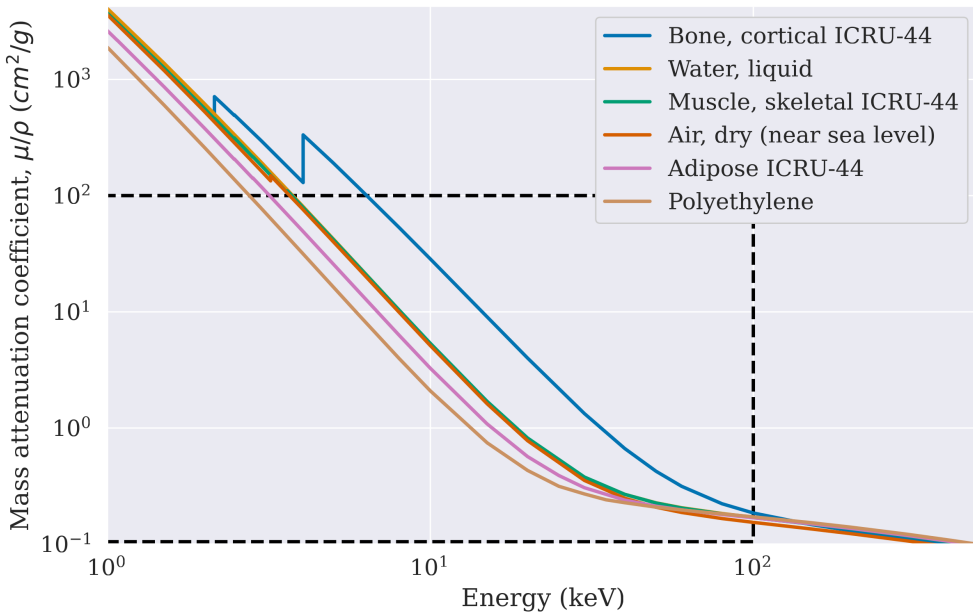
The mass attenuation coefficients, μ/ρ , for six materials of interest: cortical bone, liquid water, dry air near sea level, skeletal muscle tissue, adipose tissue and polyethylene. The materials in the legend are ordered in terms of descending average mass attenuation coefficient. The black dashed rectangle indicates the region of interest used in the subsequent plot. The data for these coefficients is compiled, updated and distributed by NIST (National Institute of Standard and Technology), USA (61) under the X-Ray Mass Attenuation Coefficients section: <https://physics.nist.gov/PhysRefData/XrayMassCoef/tab4.html>.
